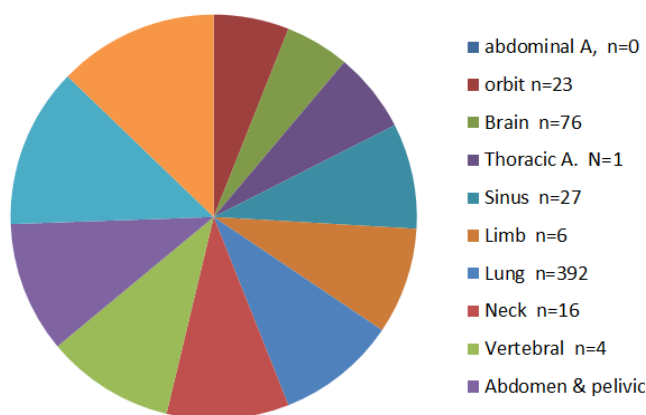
Frequency and Percentage of Abnormal CT Results by Organ
